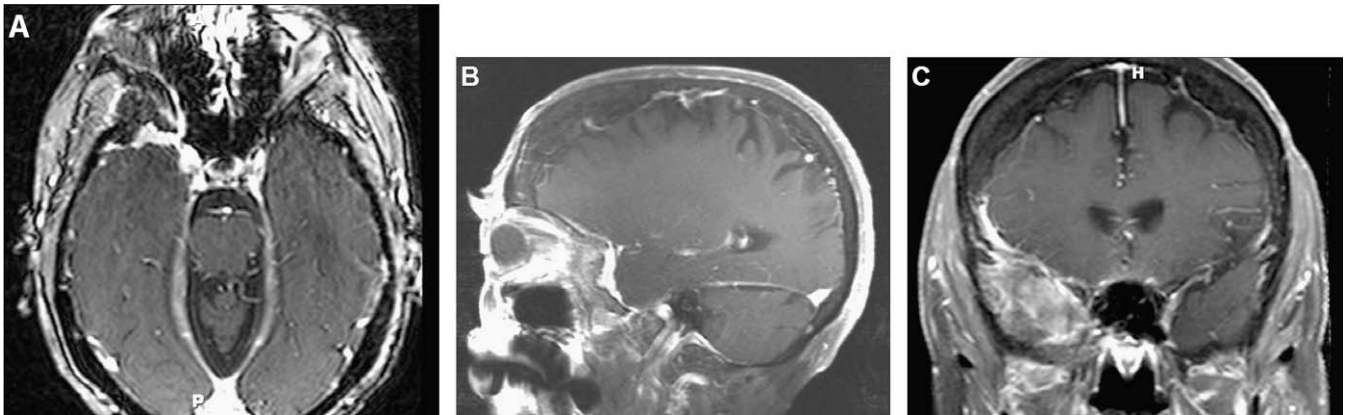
Preoperative T1-weighted MRI with contrast enhancement showing the right sphenoorbital meningioma (A, axial) encroaching on the adjacent optic nerve, (B, sagittal) growing into the petrous temporal bone, and (C, coronal) in the coronal plane growing along the sphenoid wing.
